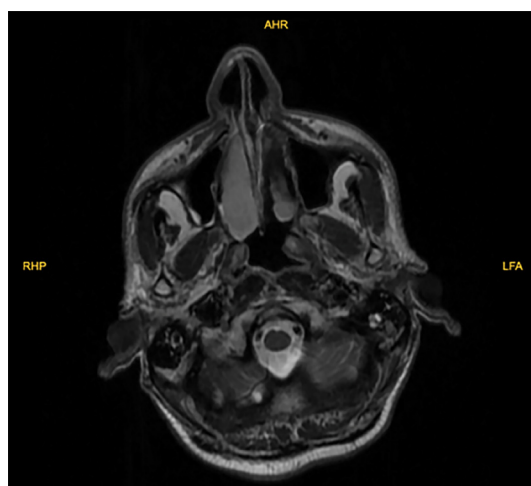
Magnetic resonance imaging (MRI) of the parapharyngeal mass at diagnosis. Axial T1-weighted MRI shows a 48×30 mm irregular parapharyngeal mass (white arrow) originating in the left Rosenmüller fossa. The lesion demonstrates cystic and necrotic components, with poorly defined borders extending into the infratemporal fossa and soft palate. Infiltration of adjacent structures, including the medial pterygoid muscle, is evident, suggesting advanced local invasion.
